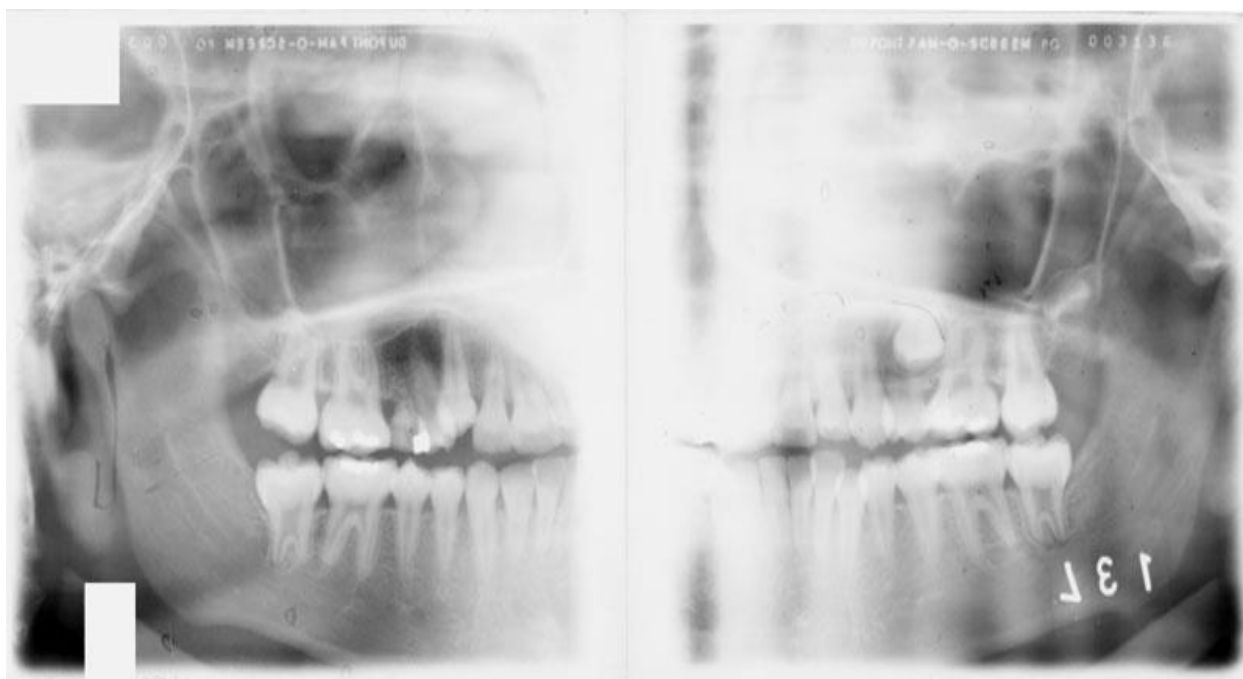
Overexposed radiograph from the Economides collection
